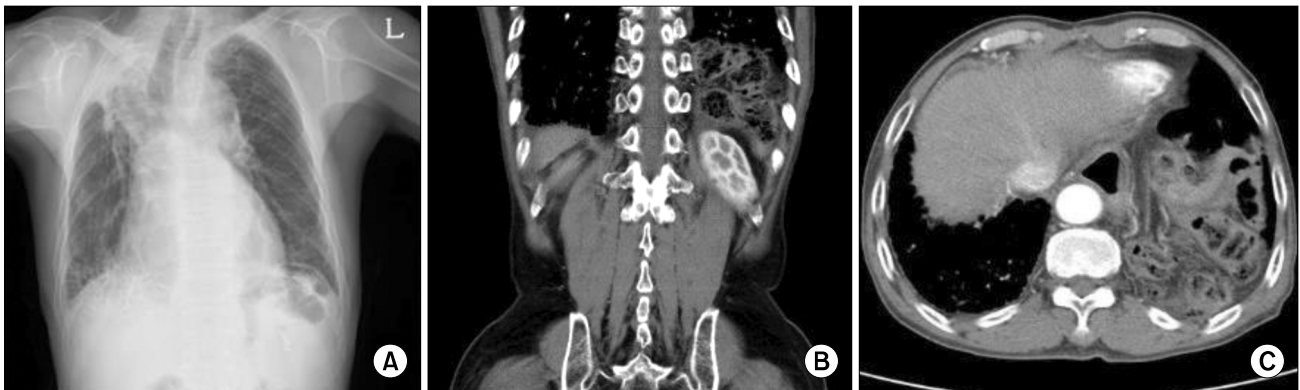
Abdominal computed tomography revealed a prominent transhiatal hernia. (A) Chest X-ray was not helpful for the diagnosis. (B, C) However, portions of the small and large bowel were seen in the left thoracic cavity on abdominal computed tomography.
